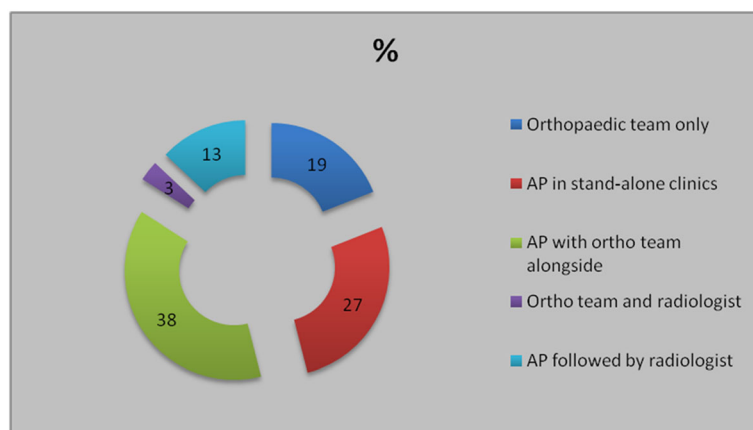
Interpretation of X-ray images in arthroplasty surveillance. AP, arthroplasty practitioner; ortho, orthopaedic
